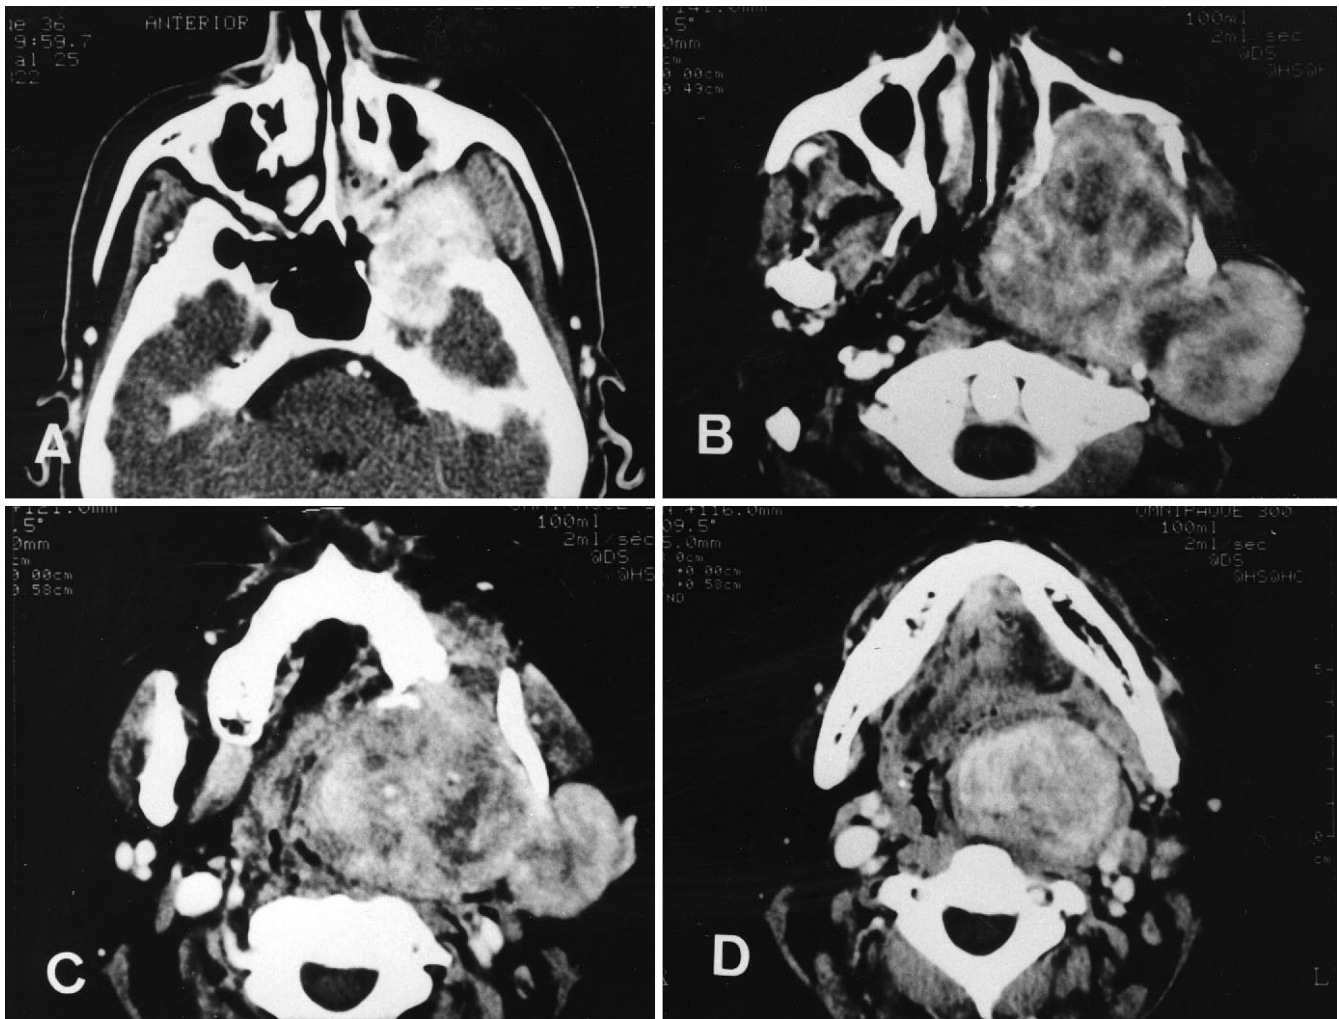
Axial computed tomography showing tumor at the levels of skull base (A), external auditory canal (B), maxilla (C) and mandible (D)
